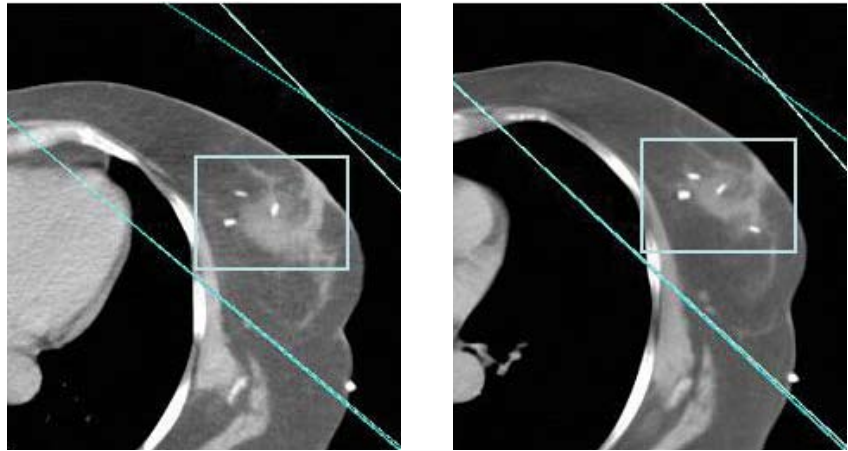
CT images (left) FB (right) mDIBH
